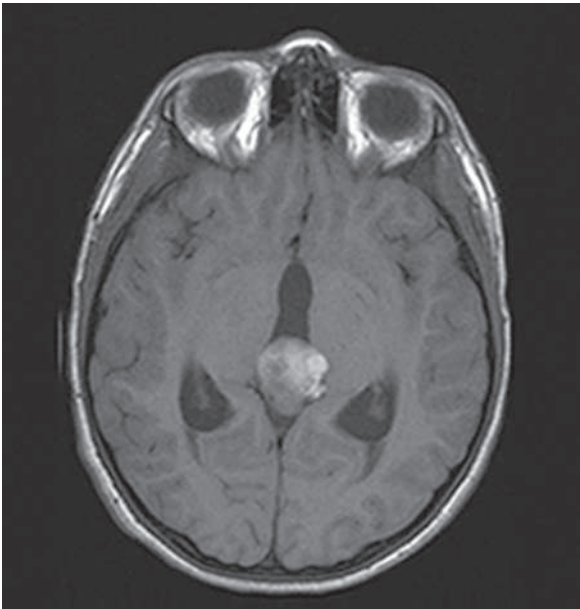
Axillary T1 weighted MR image with gadolinium of a 10-yr-old male presenting with mixed germ cell tumor of the pineal region, with early onset of puberty, headaches, and elevated α -fetoprotein and β -human chorionic gonadotropin in the spinal fluid and serum.
